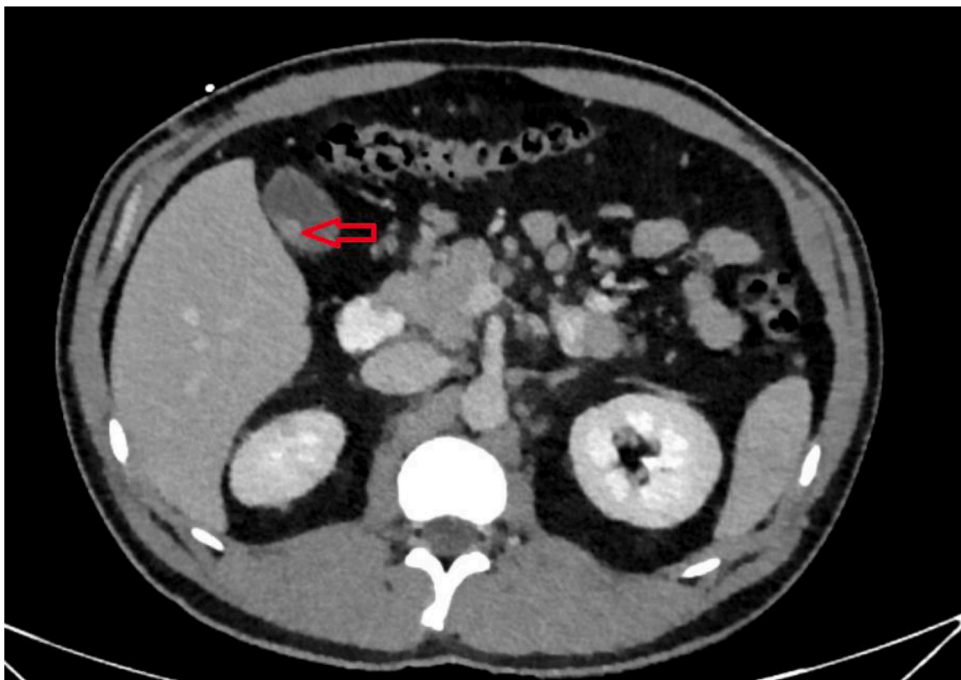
CT shows 6 mm soft tissue nodule in the posterior gallbladder (red arrow).
